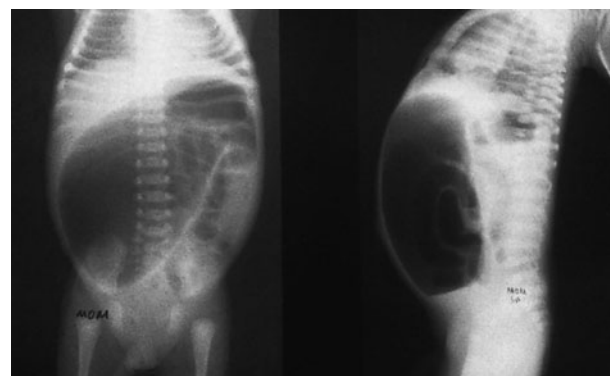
Typical roentgenogram of a giant meconium cyst. Prenatal ileal perforation was secondary to atresia of ileum.
